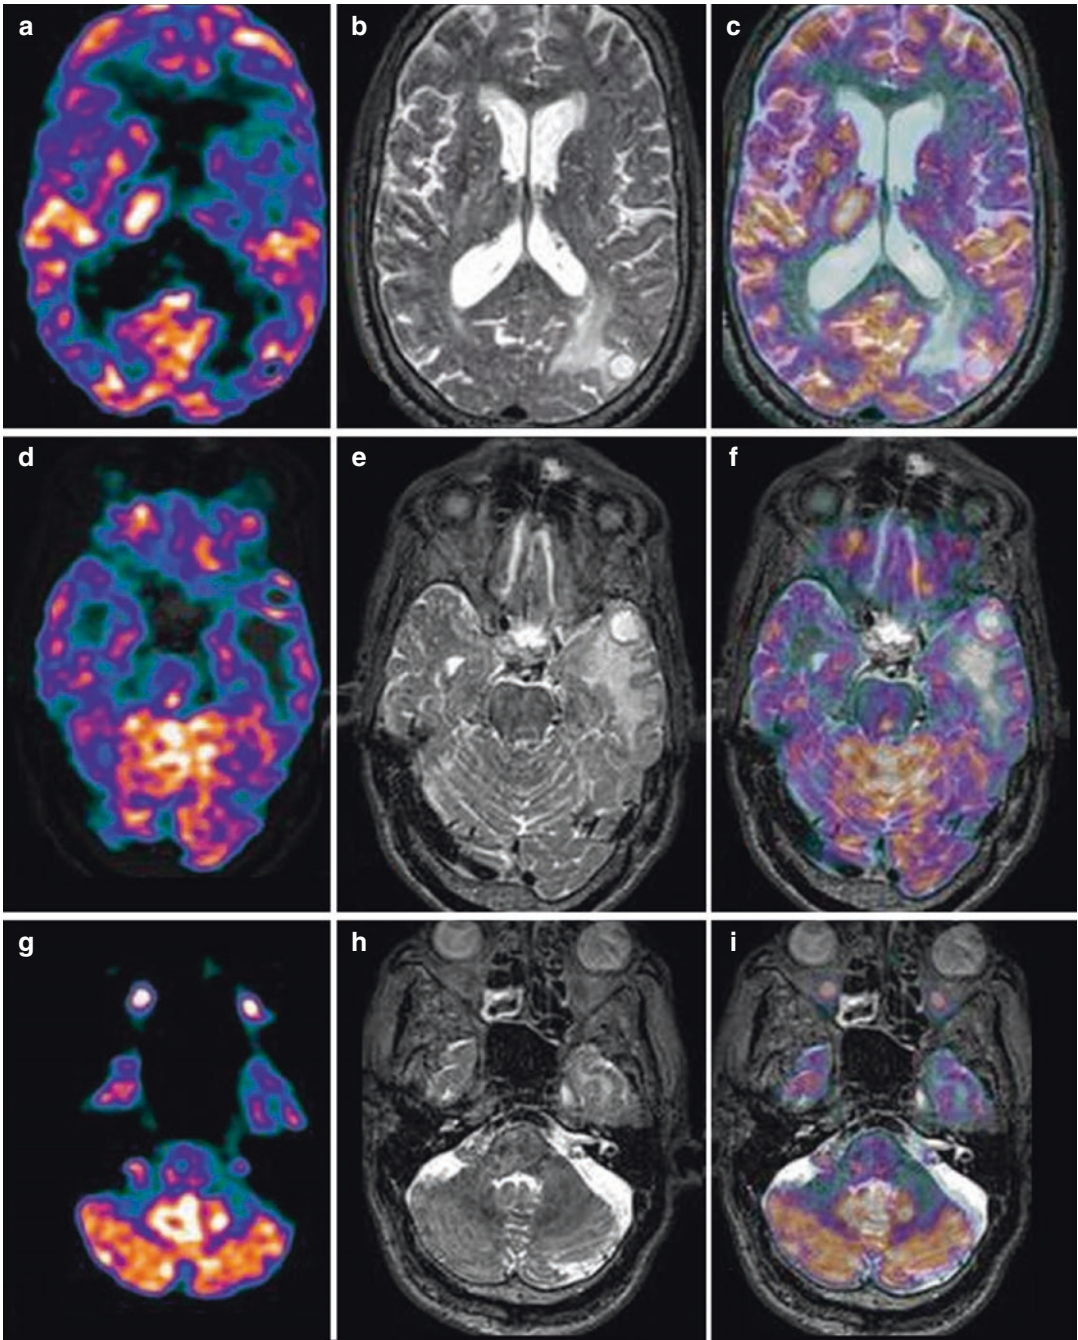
Multiple brain metastases from melanoma. In particular, an area of hypometabolism is evident in axial PET view (a) in left occipital region, in association with 1-cm-wide hyperintense lesion, with surrounding edema, in corresponding MRI (b) and PET/MRI (c) views.
